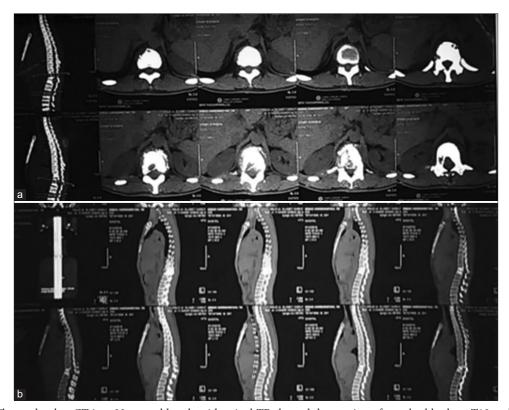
(a-b) Thoracolumbar CT in a 22-year-old male with spinal TB showed destruction of vertebral body at T12 and L1, pathological fracture at T12 and L1, and kyphotic deformity.
